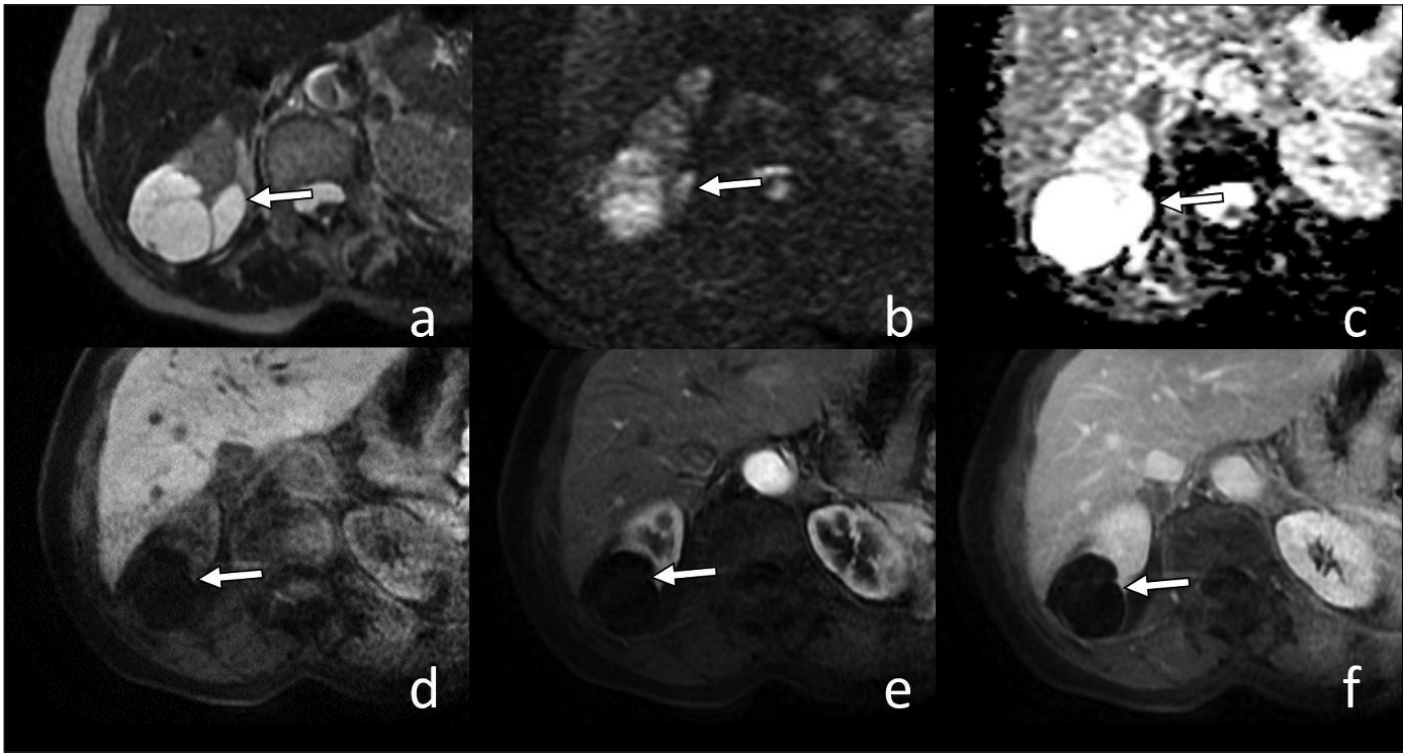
Magnetic resonance image of a complex cyst of the right kidney. (a) Hyperintense fluid content of the cyst and a few slightly thick septa within the cyst were observed on T2-weighted image (WI); (b,c) the cyst had a high signal on both diffusion-weighted imaging and apparent diffusion coefficient map; (d) precontrast and post-contrast T1-WI obtained in (e) corticomedullary and (f) nephrogram phases exhibit slight enhancement on the posterior wall and septation of the cyst. Solid component and measurable enhancement were not identified. The cyst was categorized as Bosniak category 2F.
